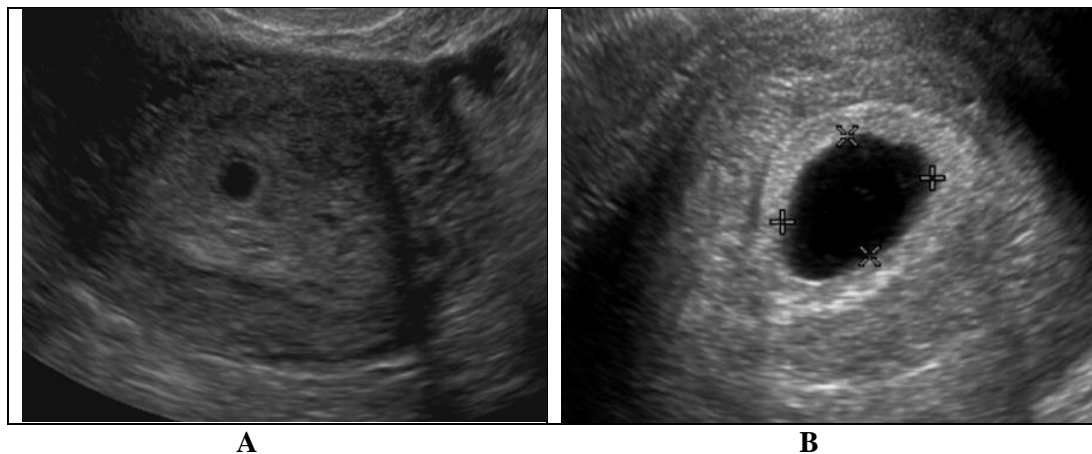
Transvaginal ultrasonography in a pregnant woman presenting with abdominal pain and cramping.
